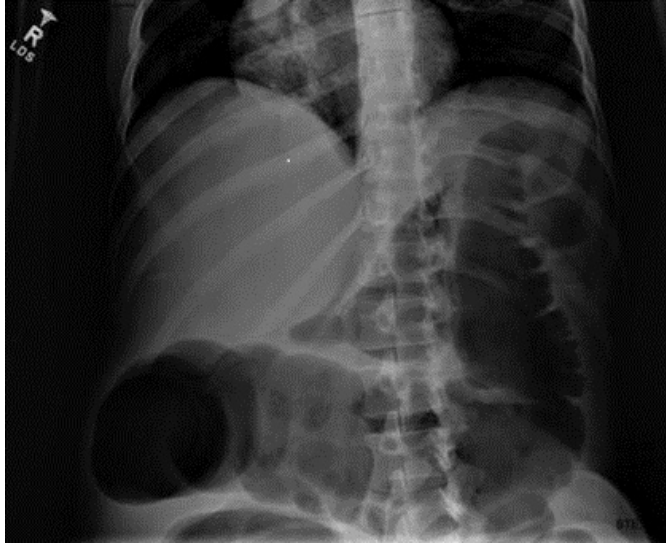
Admission x-ray of the abdomen.
